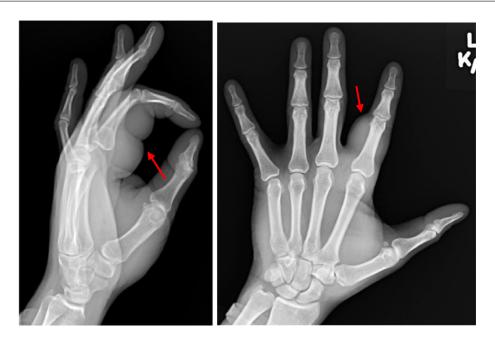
Initial radiographs of left hand with red arrows pointing to soft tissue swelling.
